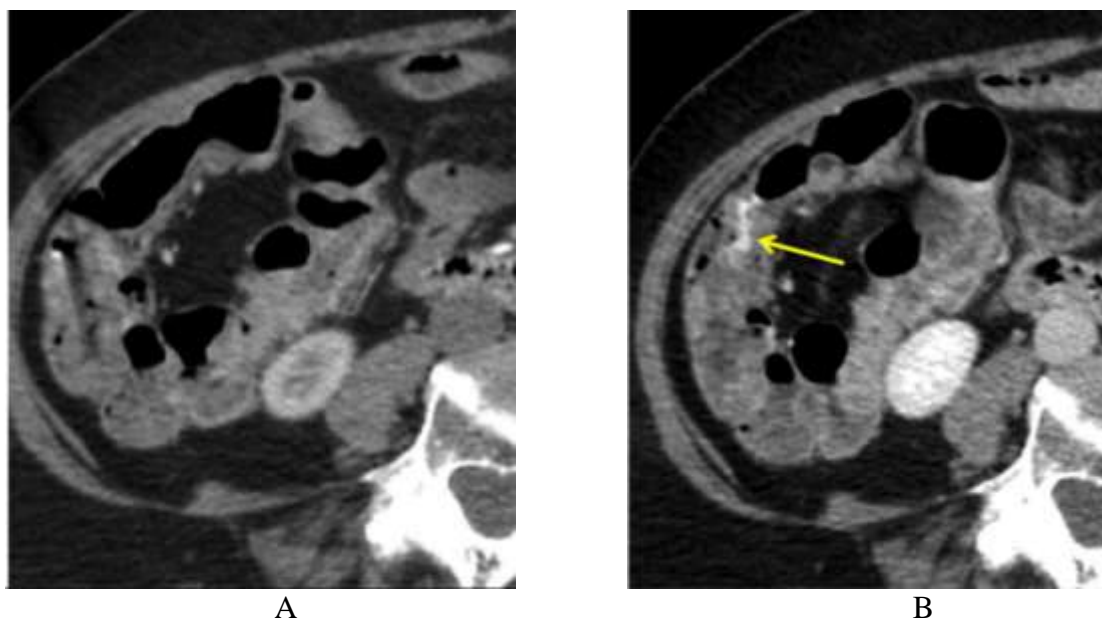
83-year-old female with delayed diverticular bleeding. On axial arterial phase CT images, no hyperattenuating material is present within the bowel lumen. On subsequent portal venous phase image (B), there is subtle contrast extravasation within the right colon (yellow arrow).
